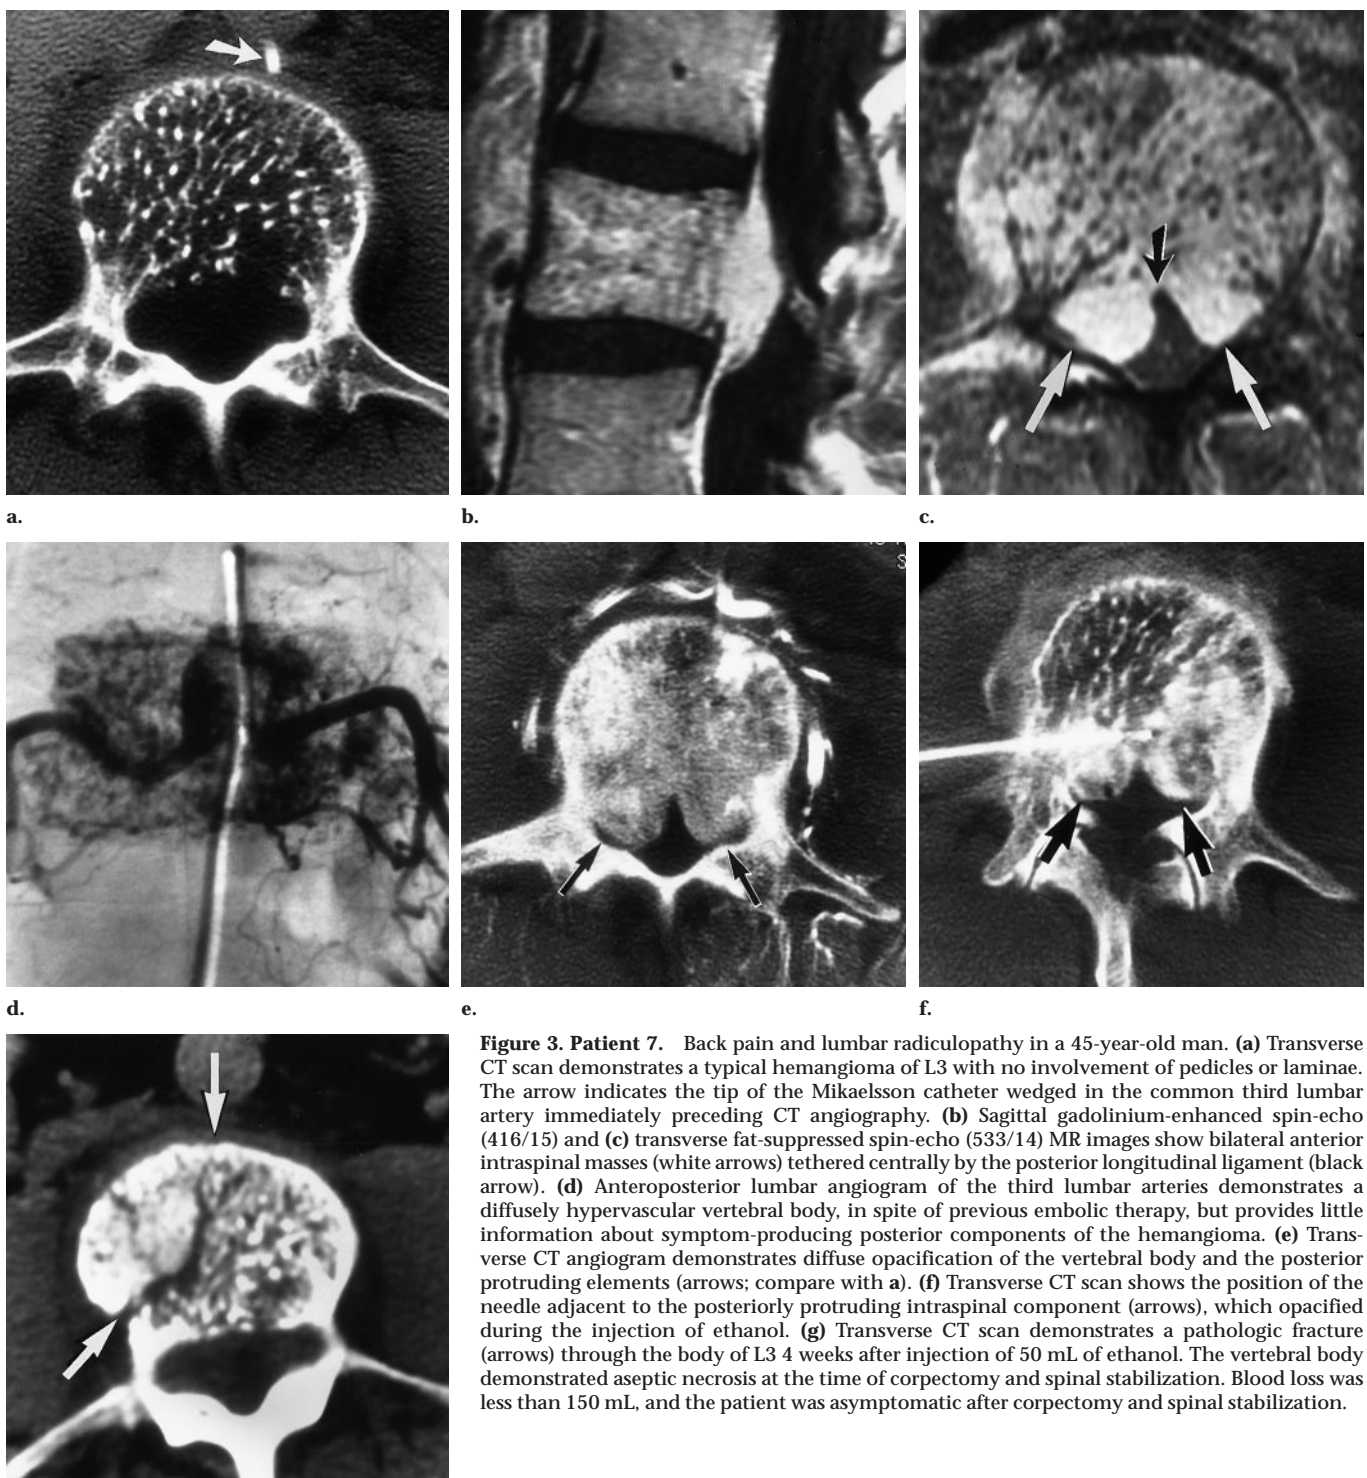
Patient 7. Back pain and lumbar radiculopathy in a 45-year-old man. (a) Transverse CT scan demonstrates a typical hemangioma of L3 with no involvement of pedicles or laminae. The arrow indicates the tip of the Mikaelsson catheter wedged in the common third lumbar artery immediately preceding CT angiography. (b) Sagittal gadolinium-enhanced spin-echo (416/15) and (c) transverse fat-suppressed spin-echo (533/14) MR images show bilateral anterior intraspinal masses (white arrows) tethered centrally by the posterior longitudinal ligament (black arrow). (d) Anteroposterior lumbar angiogram of the third lumbar arteries demonstrates a diffusely hypervascular vertebral body, in spite of previous embolic therapy, but provides little information about symptom-producing posterior components of the hemangioma. (e) Transverse CT angiogram demonstrates diffuse opacification of the vertebral body and the posterior protruding elements (arrows; compare with a). (f) Transverse CT scan shows the position of the needle adjacent to the posteriorly protruding intraspinal component (arrows), which opacified during the injection of ethanol. (g) Transverse CT scan demonstrates a pathologic fracture (arrows) through the body of L3 4 weeks after injection of 50 mL of ethanol. The vertebral body demonstrated aseptic necrosis at the time of corpectomy and spinal stabilization. Blood loss was less than 150 mL, and the patient was asymptomatic after corpectomy and spinal stabilization.
